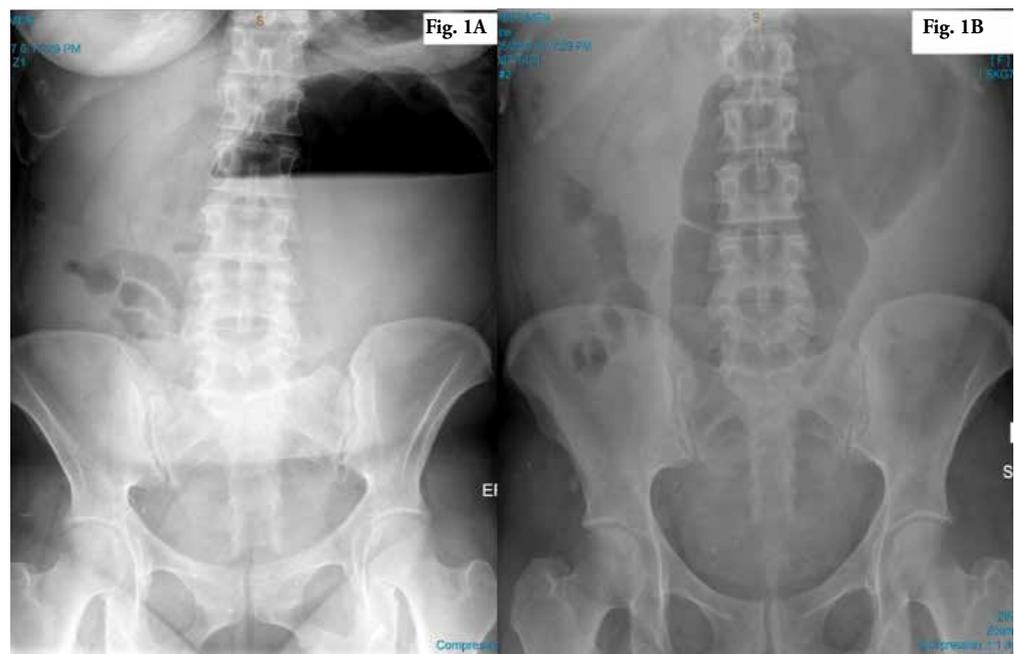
Erect abdominal x-ray showing a dominant, dilated large bowel loop with air fluid level.
